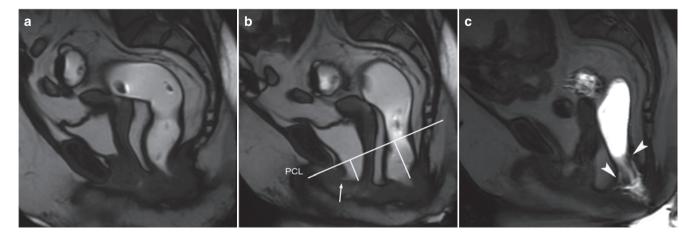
54-year old female patient with urinary incontinence and slight outlet obstruction. Midsagittal T2-weighted trueFISP MR image at rest (a) shows a normal position of the pelvic floor. At straining (b) a pathologic descent of the bladder (2.2 cm) and anorectal junction
